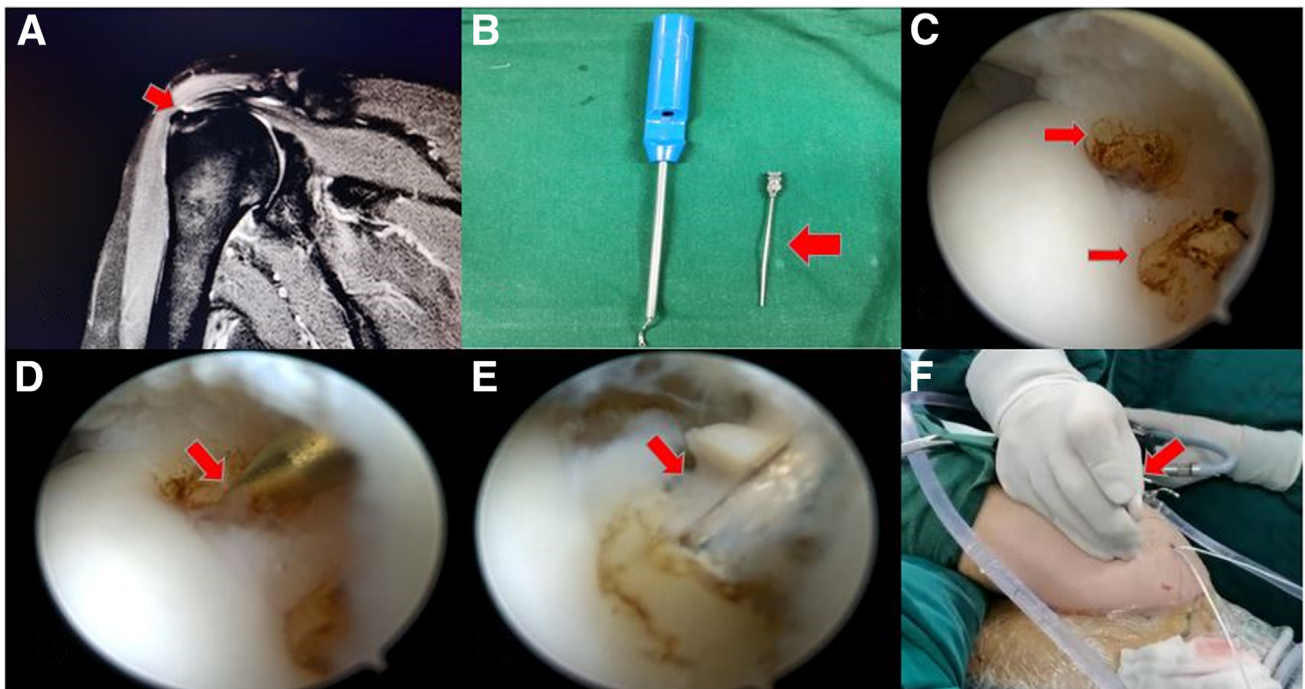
(A) Preoperative coronal T2-weighted fat-saturated magnetic resonance image showing the rotator cuff tear (RCT) (red arrow) (right shoulder, lateral position). (B) Photograph of the spinal needle used for RCT repair. (C) Intraoperative photographs showing the selection of drill hole locations under direct joint cavity visualization, with a plasma knife marking the anchor placement site. The number of holes is contingent on the size of the tear. (D) Drilling. (E) The Implant Footprint Ultra PK Suture Anchor (Smith & Nephew). (F) Introduction of the spinal needle through the anterior and upper aspect of the shoulder, traversing skin, subcutaneous tissue, and the rotator cuff.
